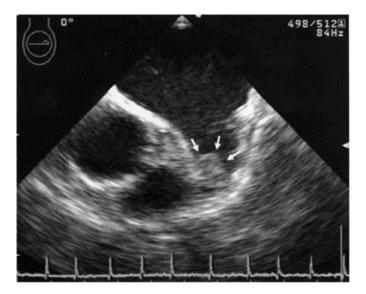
Thrombus in the left atrial appendage (arrows) demonstrated by transesophageal echocardiography.
